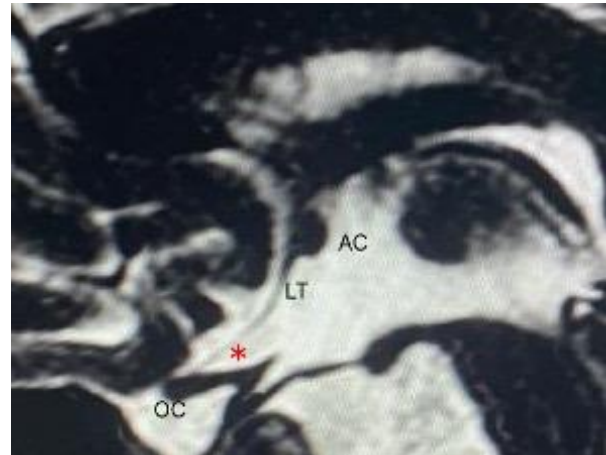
Mid sagittal MRI T2 shows chiasmatic recess (red star), the optic chiasm (OC), lamina terminalis (LT) and anterior commissure (AC).
